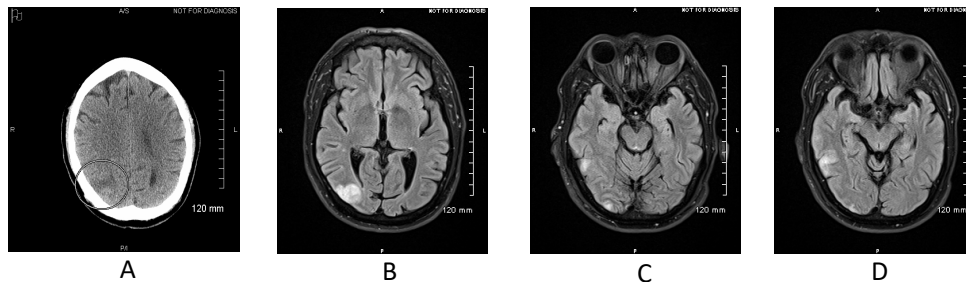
A) CT Brain Without Contrast: Focal area of decreased attenuation extending through the cortex in the posterior parietal region on the right B-D) MRI Brain With/Without Contrast: Focal Abnormal T2 FLAIR high signal involving the cortical aspects of the right occipital lobe and right temporal lobe
